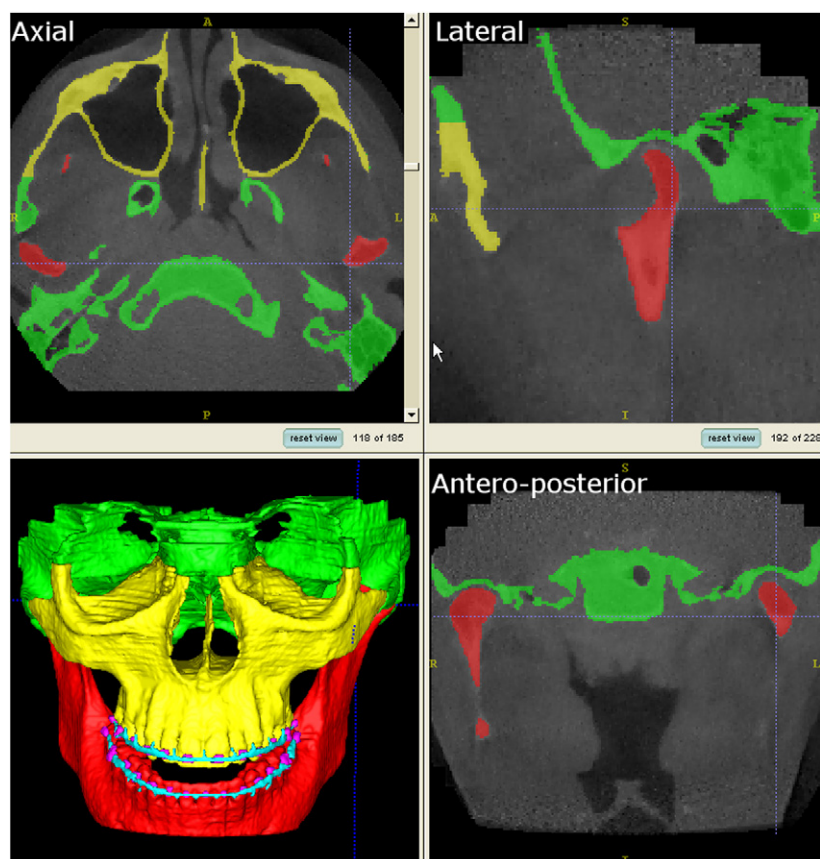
CBCT images are imported as DICOM files into ITK-SNAP. In a process called semiautomatic segmentation, anatomic areas of interest are identified and delineated. Manual editing is performed to ensure accuracy of the segmentations. The images can be viewed in 3 dimensions and as axial, coronal, and sagittal slices of each image.
